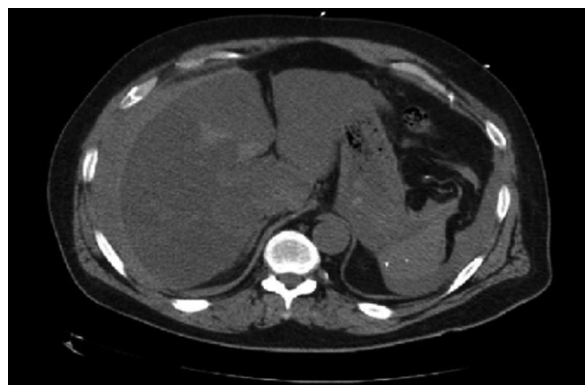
Computed tomography showing acute peritoneal hemorrhage. Fluid is prominent surrounding the second and third portions of the duodenum and pancreatic head, and perihepatic regions.
